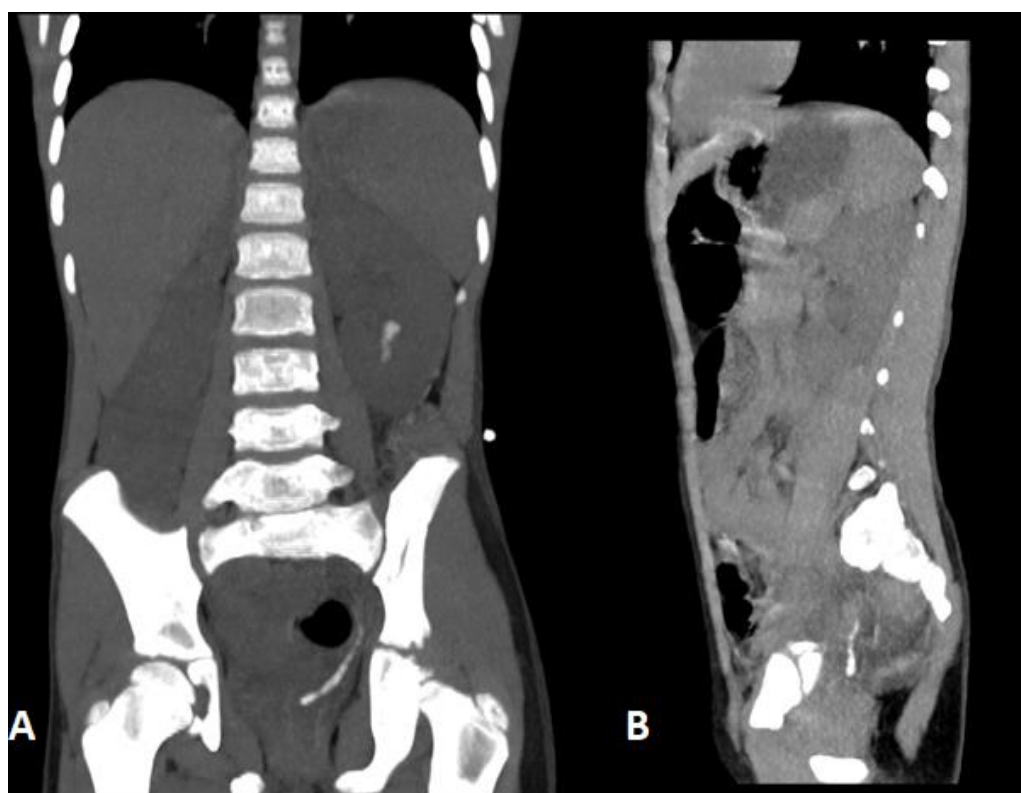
CT scan without contrast (Coronal (A) and sagittal (B) views): 4 cm left distal ureteric stones and small left kidney stones.
